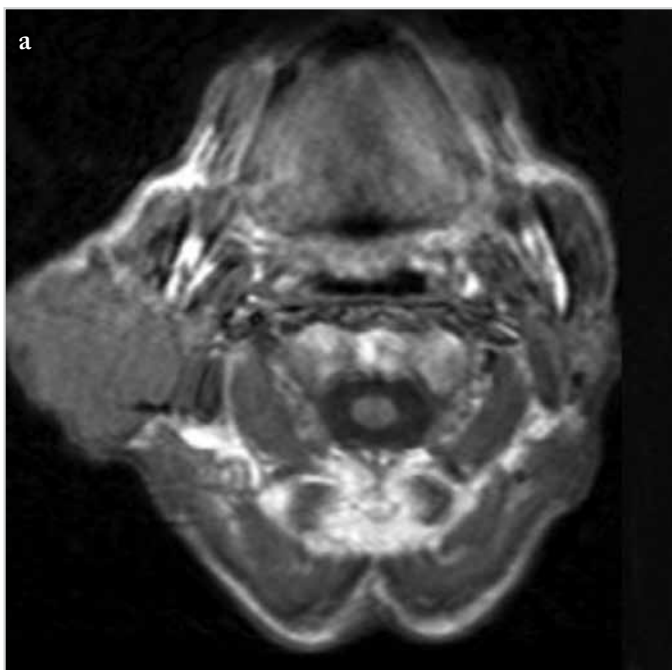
a, b. MRI imaging of the mass showing the right parotid deep lobe extension in patient no. 5. (a) The isointense appearance of the mass is observed in the T1-weighted section. (b) The hyperintense and multifocal appearance of the mass is remarkable in the T2-weighted section
